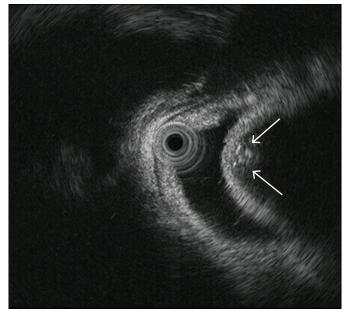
Endoscopic ultrasound revealing granular calcification in the tumor (arrows).
